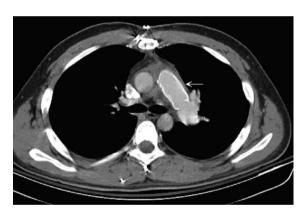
Chest computed tomography 1 month later, showing patent vascular graft with normal size (arrow).
